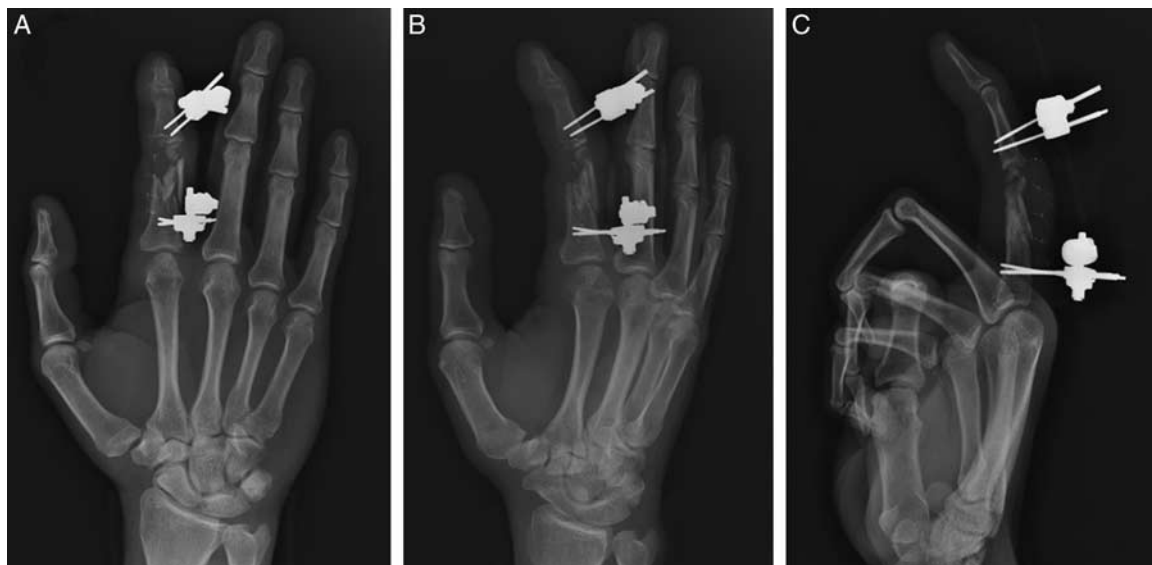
A–C, X-ray of hand on February 27, 2018.
